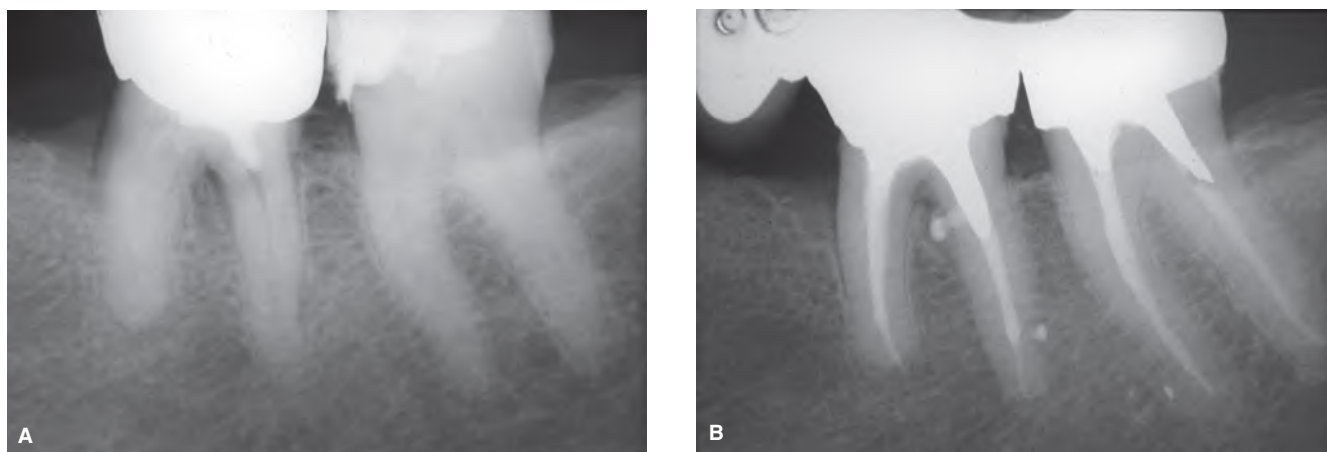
A. The mandibular left first molar is scheduled to be retreated prior to initiating a full mouth restoration. B. Five-year recall radiograph showing evidence of complete healing of the furcation area.
